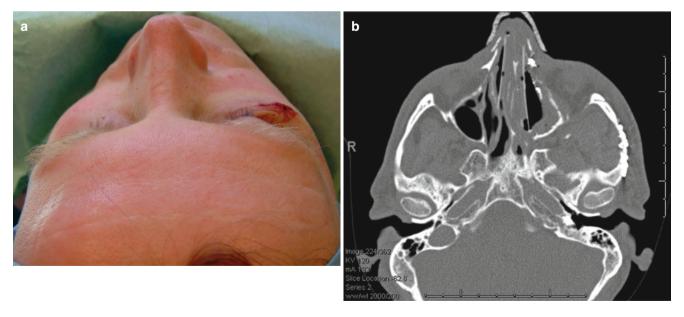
Good cheek projection following repair (a). Even so, if one looks critically at the arch on the CT image (b), there is still a minor degree of residual deformation
